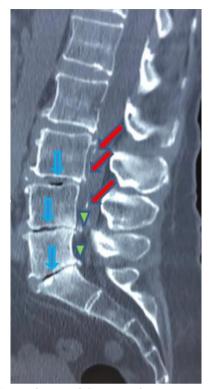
Lumbosacral CT sagittal reconstruction with bone algorithms: calcific epiduritis (red arrows), degenerative disc diseases L3-L4, L4-L5 and L5-S1 with vacuum disk (blue arrows) and partially L4-L5 and L5-S1 protrusions calcifications (arrowheads).
